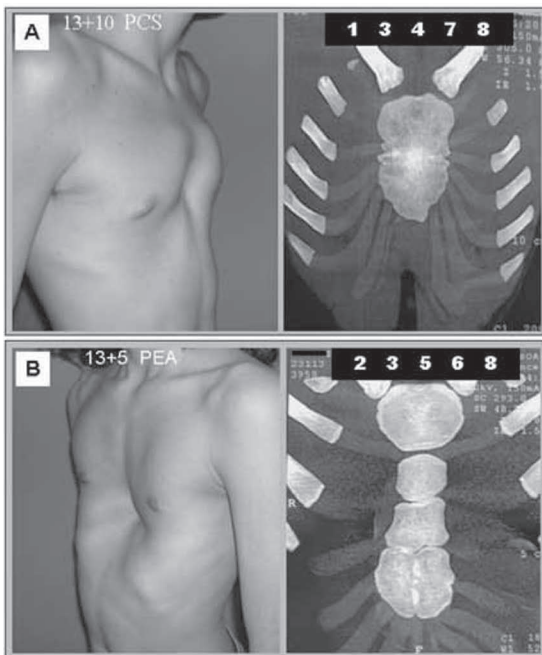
Examples of appearances found in the coronal reconstruction of multislice CT of the chest in adolescents with (A) superior pectus carinatum (SPC) and (B) severe pectus excavatum (SPE); both were 13 years old. Appearances include 3) asymmetry of the thorax and costal cartilages, 8) evident enlargement of the sternal body was found in both, while the appearance of 1) ossification and fusion of the xiphoid to the body, 4) ossification and fusion of the manubrium to the body, and 7) fusion of all segments of the sternal body are visible only in (A) and the appearance of 2) lateral irregularity in sternal body morphology, 5) irregularity in the cartilaginous growth plates of the sternum, and 6) incomplete fusion of the longitudinal bands of embryonic origin of the sternum are seen only in (B).
